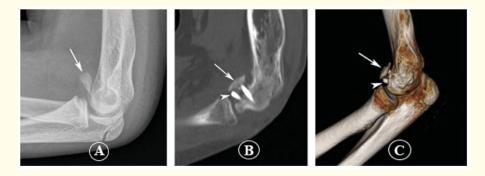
18C: Postoperative fixation of capitellar osteochondral fracture in an 11-year-old boy. A: Lateral elbow radiograph shows a proximally displaced and rotated anterior capitellar osteochondral fracture in a boy who fell off his bike and landed on his elbow. B: Sagittal two-dimensional and C: Three-dimensional surface rendered images obtained 3 weeks after open reduction and internal fixation of the capitellar defect with two Acutrak Mini screws (Acumed, Hillsboro, OR) (arrowheads). The osteochondral fragment (arrows) has been reduced to near anatomical alignment and incorporated before screw removal 6 weeks later.
